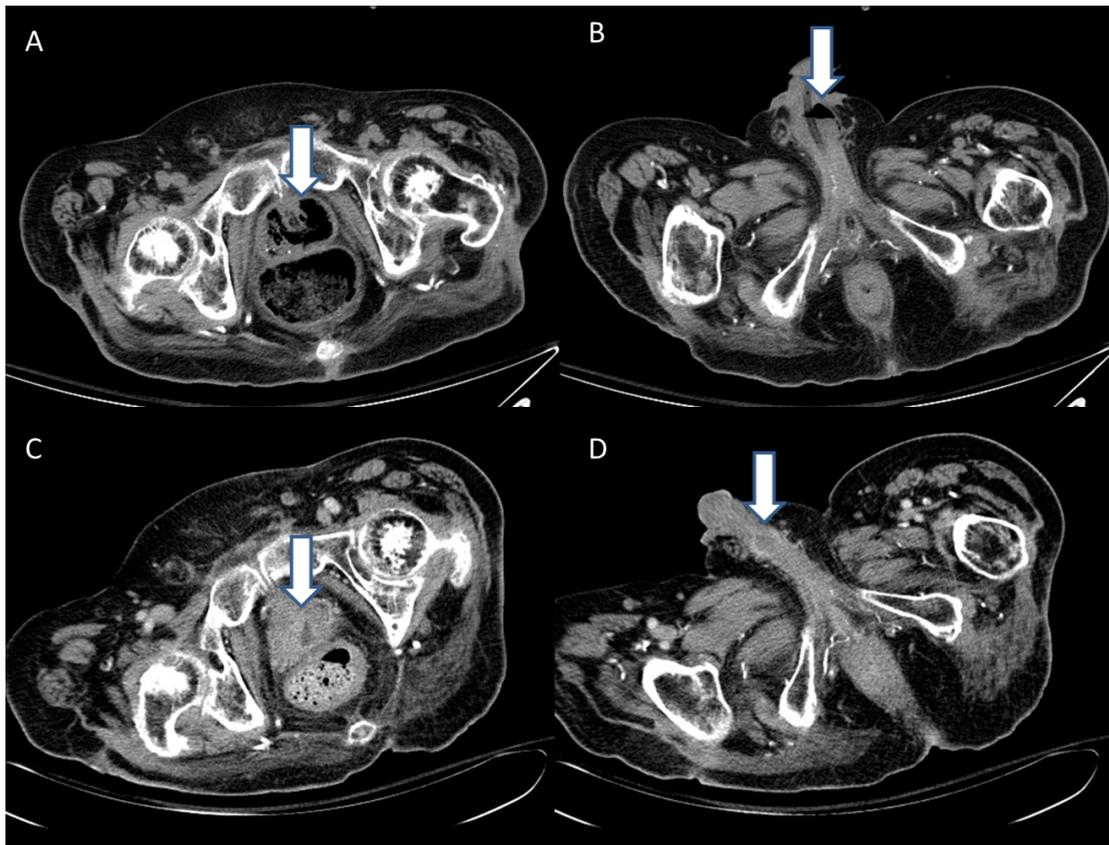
Computed tomography of the abdomen on Day 1 of hospitalization showing abscesses with gas in the prostate (A, arrow) and corpus spongiosum (B, arrow). Computed tomography of the abdomen on Day 24 of hospitalization, after transperineal drainage, suprapubic cystostomy and intravenous antimicrobial therapy showing resolution of the abscesses in the prostate (C, arrow) and corpus spongiosum (D, arrow).
